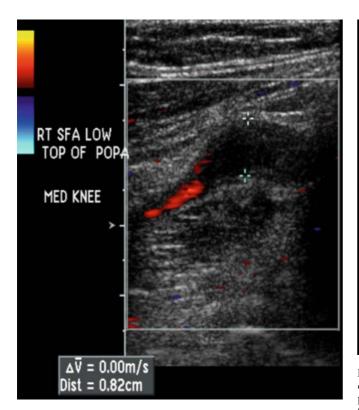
Longitudinal color Doppler image demonstrating thrombosed aneurysm of the right popliteal artery
